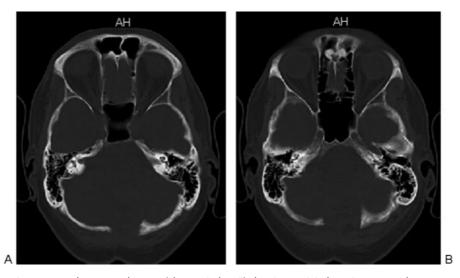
(A, B) Postoperative computed tomography scan ("bone windows") showing occipital craniectomy with recurrence-free removal of xanthoma on 5-year follow-up image.
